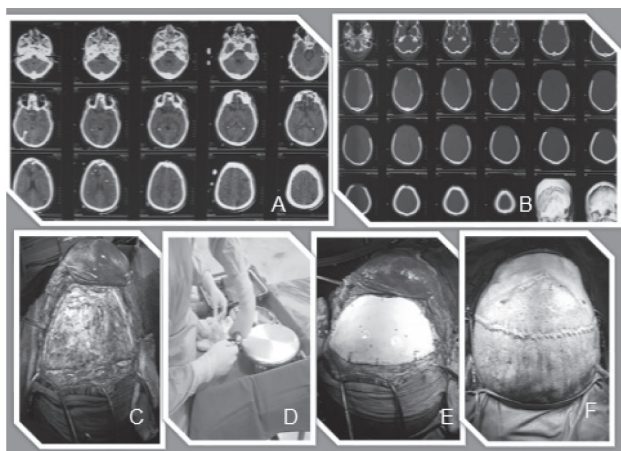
A) Showing the preoperative CT, B) Bi-Frontal decompressive craniectomy CT, C) Preparation of the flap, D) Mixing the bone cement, E) Completion of the BCC and fixation with non-absorbable sutures and F) closure of the wound in continuous suture
